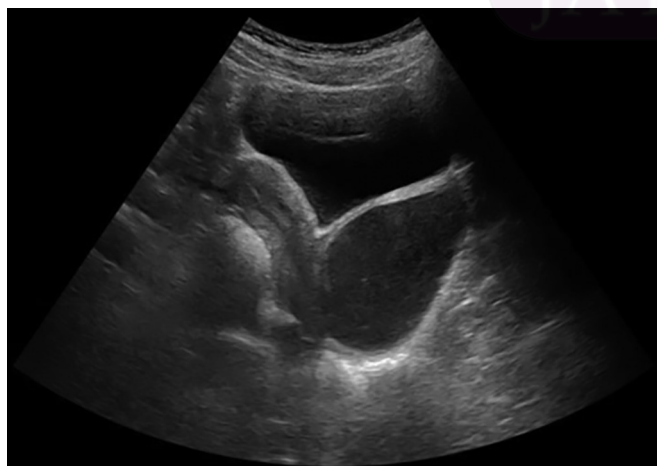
Transabdominal pelvic ultrasound (sagittal view) demonstrating uterine didelphys with right hematocolpos due to distal obstruction from a transverse vaginal septum. The vagina containing the echogenic material
